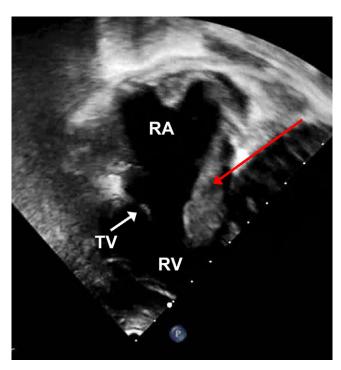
Echocardiogram (apical view) after tissue plasminogen activator depicting pedunculated thrombus in right atrium (red arrow) prolapsing through the tricuspid valve (TV) in diastole. RA=right atrium; RV=right ventricle.
